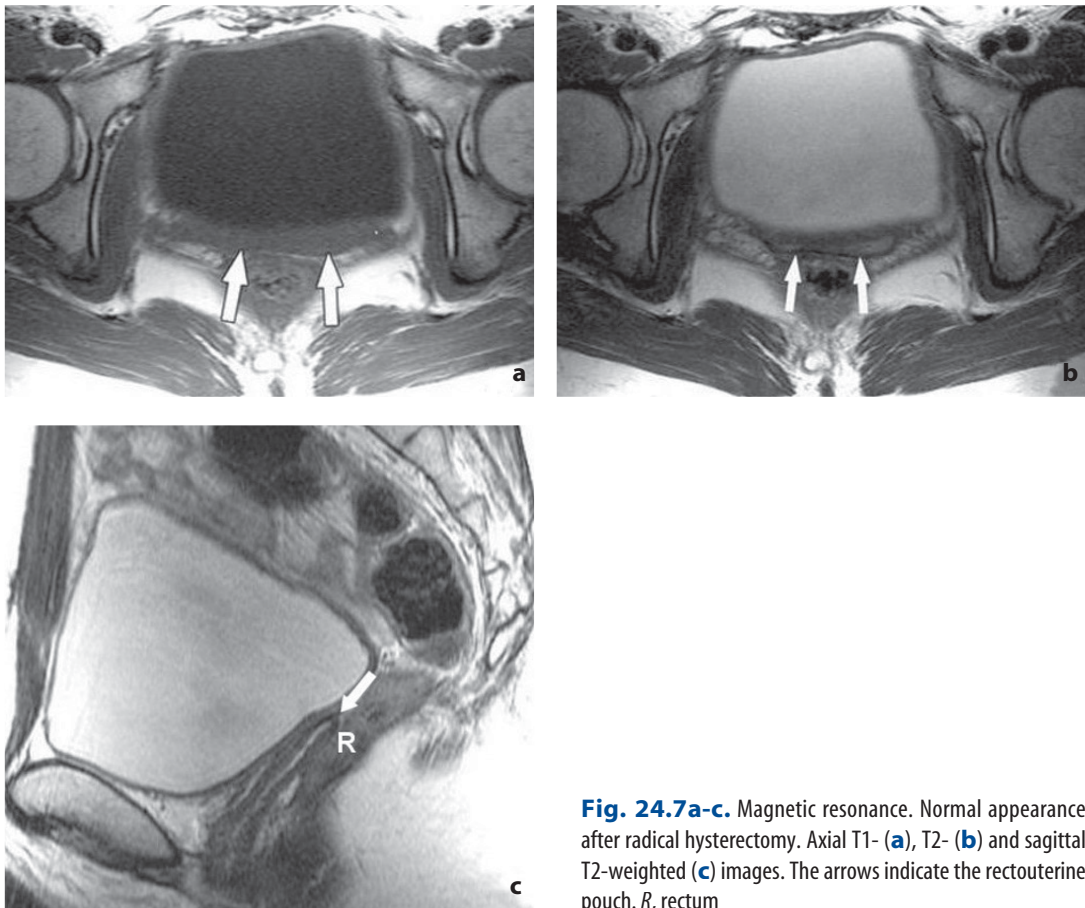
Magnetic resonance. Normal appearance after radical hysterectomy. Axial T1- (a), T2- (b) and sagittal T2-weighted (c) images. The arrows indicate the rectouterine pouch. R, rectum
